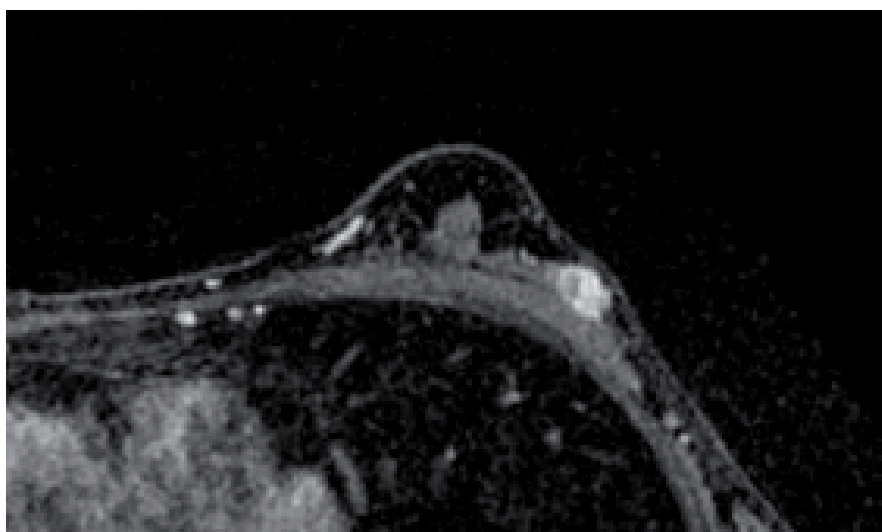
A first representative case of IDC, MRI.
